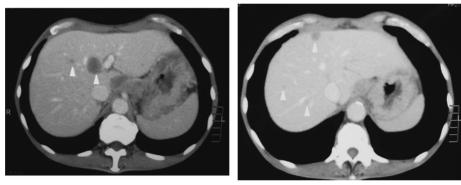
A CT scan of the abdomen with contrast enhancement. Several nonenhanced tumors (\blacktriangle) were detected in the liver.
